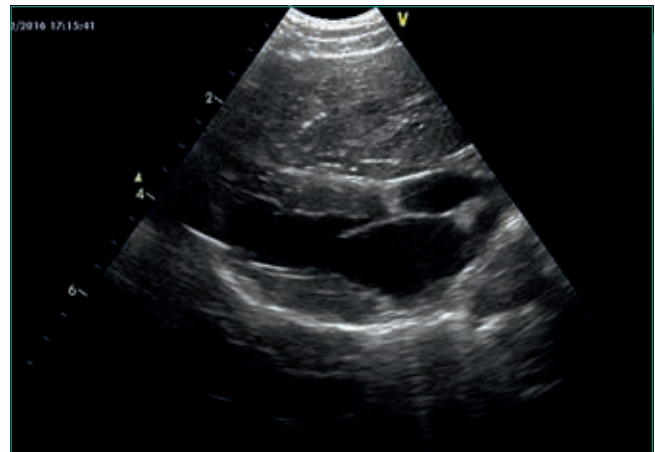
Ultrasound of a patient with peritoneopericardial diaphragmatic hernia. A piece of hepatic parenchyma is visible in the pericardium.
